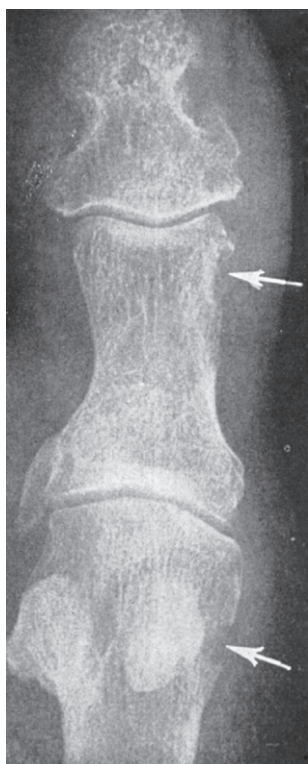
Chronic tophaceous gout. Radiograph showing characteristic punched-out erosions with overhanging margins (arrowed)
